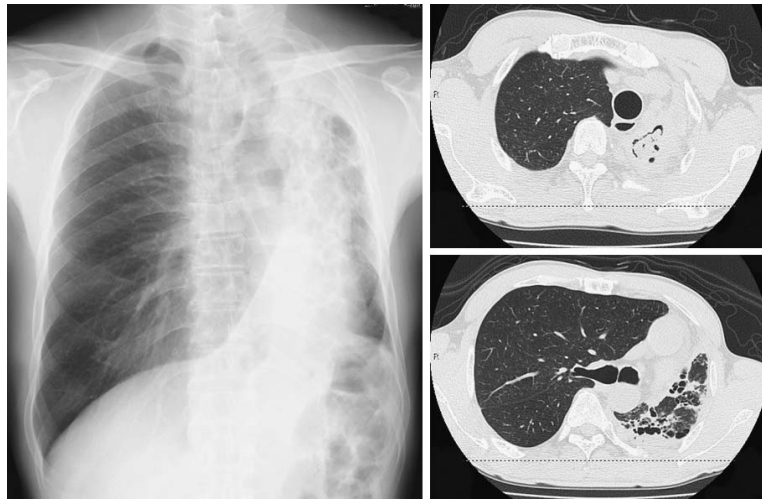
Chest X-ray films on admission demonstrated pericavity infiltrative shadows with cavitation, indicating possible aspergilloma of the left upper lung field, with no significant abnormality of the right lung.
